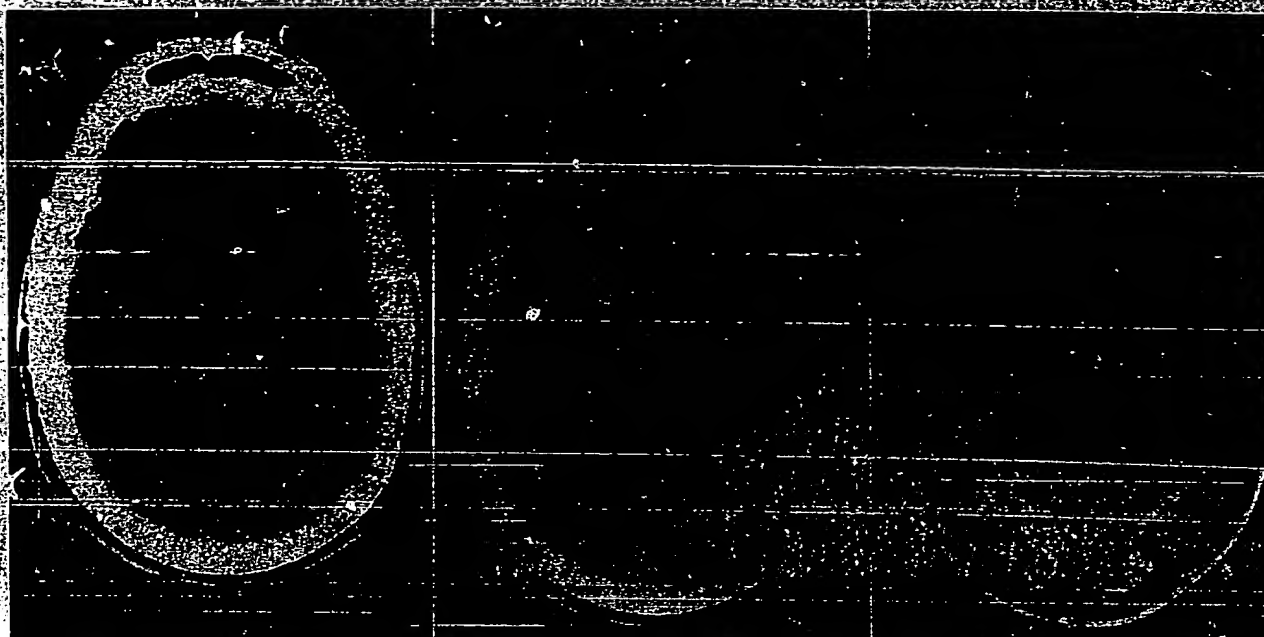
Computed tomographic (CT) and magnetic resonance (MR) scans before and after fetal tissue implantation. The left-hand panel shows the CT baseline established in the putamen for transplant. A total of six needle passes, 4-cm apart, terminated at this line. The center panel shows the CT baseline through the caudate to which four needle passes were made. The right-hand panel shows a T₁-weighted MR image obtained 5 months after surgery. The arrows point to the line of the needle tracks in the caudate and putamen. Evidence of the needle tracks is still seen. Gadolinium injection showed no enhancement at 5 months, indicating that the blood-brain barrier was intact.
